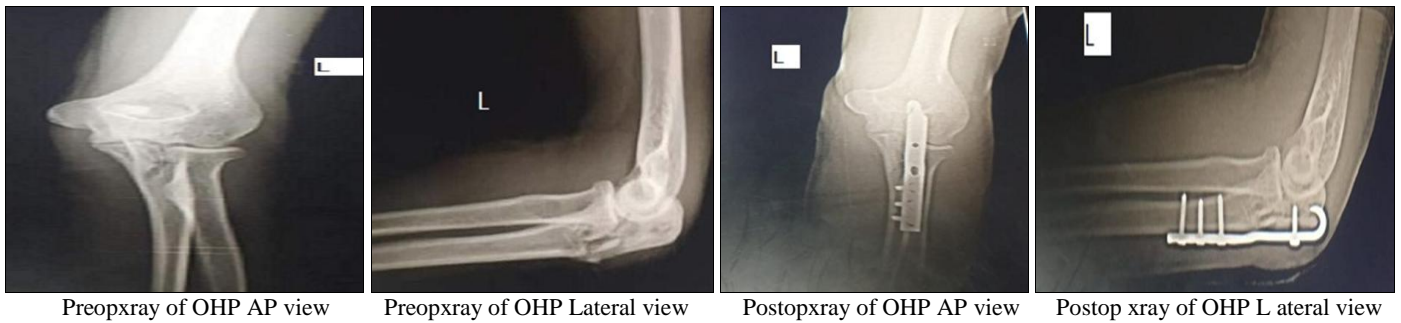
Preoperative and post operative x-rays of olecranon hook plate (OHP) fixation
